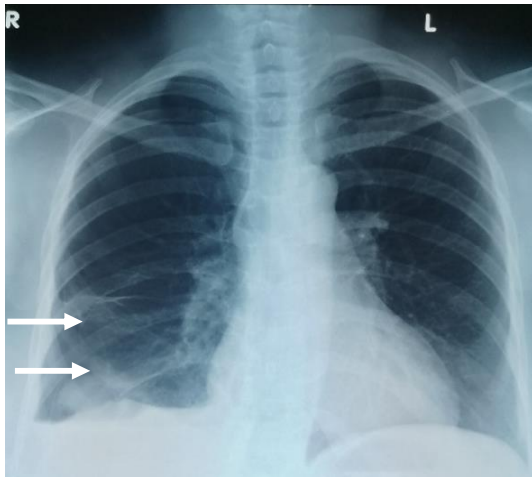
Chest x-ray showing right pneumothorax (arrows).
